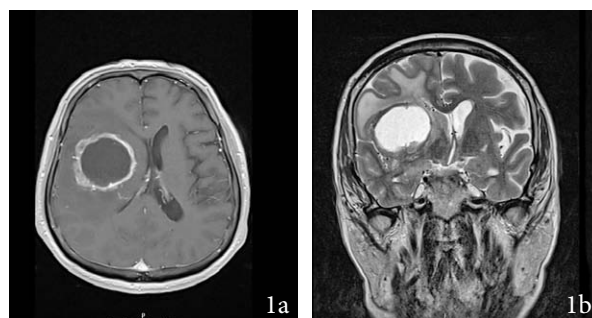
a Preoperative axial contrast-enhanced T1-weighted MR image showing a right-sided cystic lesion in the basal ganglia, with peripheral contrast enhancement.
